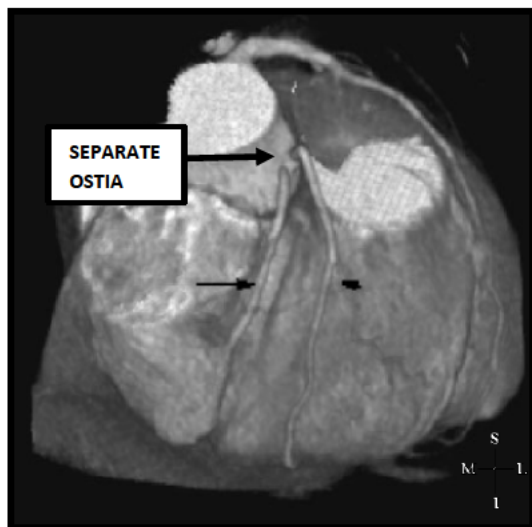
Volume rendered coronary CT angiographic image showing a double RCA arising from separate ostia. (Black arrows showing separate RCA branches) (right lateral view) (Adapted from Karaosmanoglu *et al.*, 2008)
